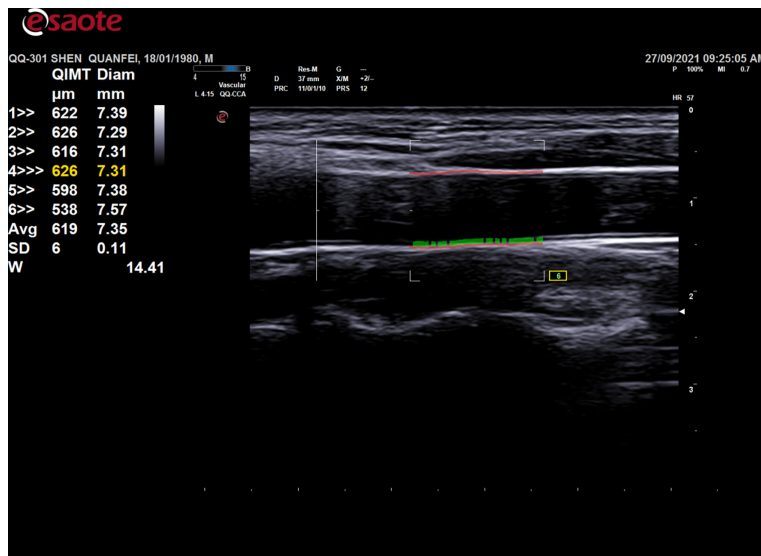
QIMT ultrasonic image of IMT detection (—:external wall of the carotid artery; —: IMT thickness). QIMT, Quality Intima-media Thickness; IMT, Intima-media Thickness.
